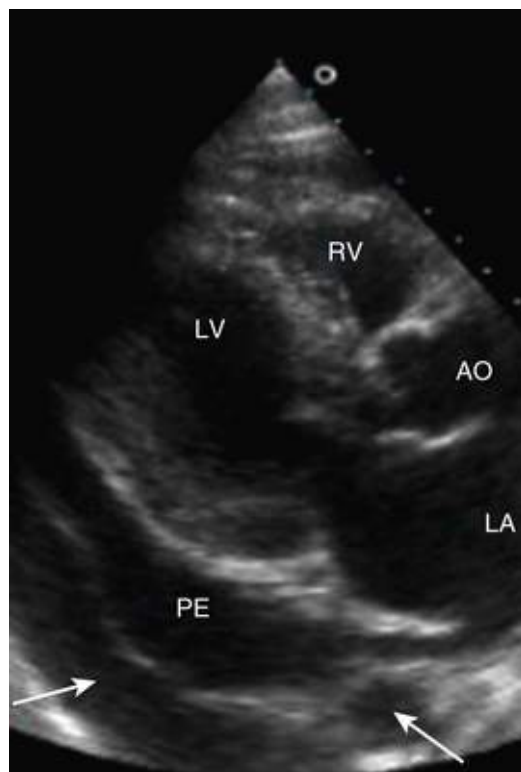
Pericardial effusion. A parasternal long-axis view shows both pericardial effusion (*PE*) and pleural effusion (*short arrow*). Note that the descending thoracic aorta (*long arrow*) is displaced from the heart by the pericardial effusion. With isolated pleural effusion, the descending aorta (*Ao*) remains immediately posterior to the heart. In this case the pericardial effusion extends posterior to the left atrium (*LA*), although this is not always the case. *LV*, Left ventricle; *RV*, right ventricle.
